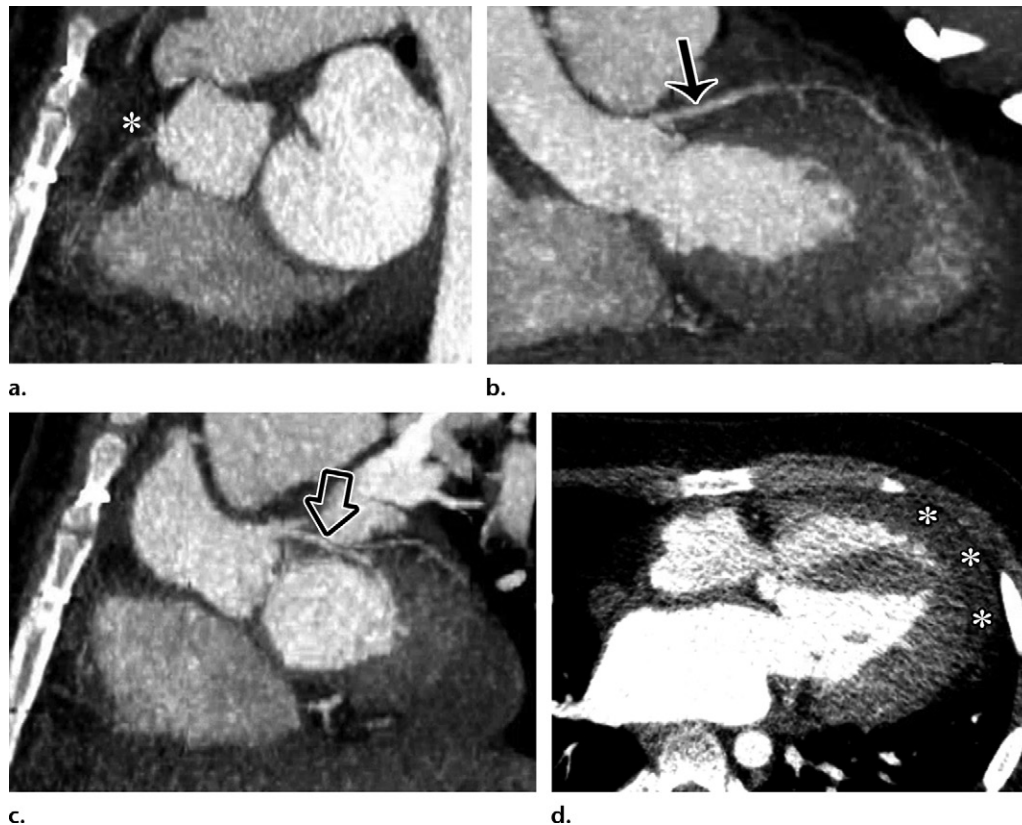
CAV in a 16-year-old adolescent boy with a history of orthotopic heart transplant 4 years previously for dilated cardiomyopathy, now with worsening diastolic dysfunction. (a–c) Curved planar reformatted images from coronary CT angiography demonstrate a diffusely diminutive RCA (* in a), LAD (arrow in b), and LCx (arrow in c) with diffuse mural thickening and luminal narrowing. (d) Axial coronary CT angiographic image shows pericardial effusion (*). Although pericardial effusion has not been described in the setting of CAV, it may occur for many reasons in the posttransplant patient, including as a result of rejection (43) or secondary to immunosuppressant medications (44).
